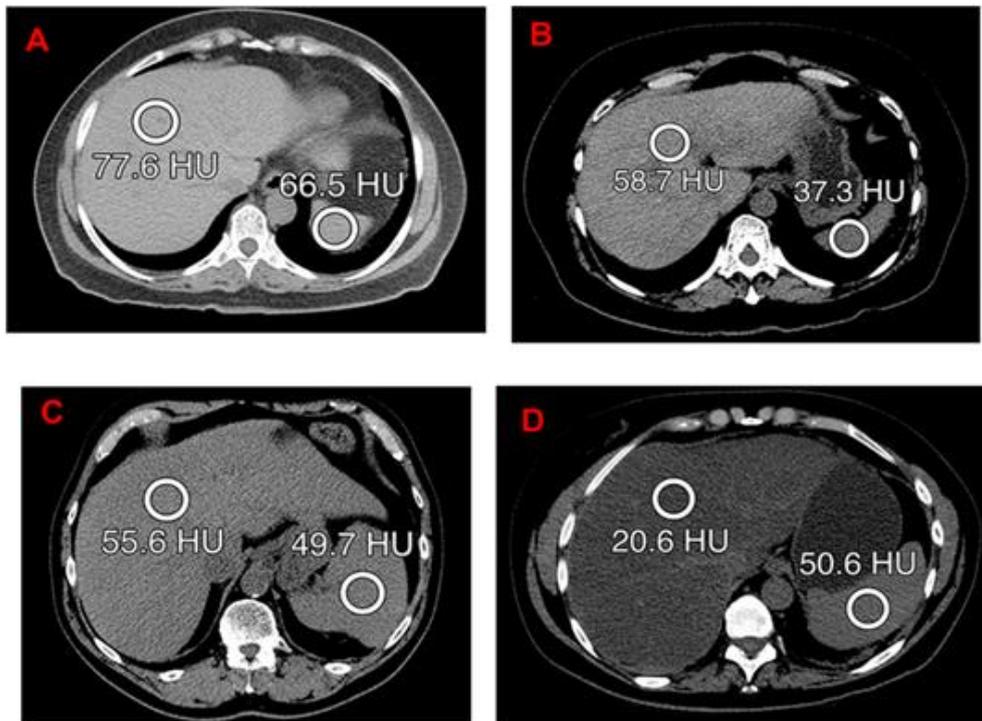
CT images of the liver at the level of the spleen, liver density on CT in Hounsfield Units decreases though spleen density in Hounsfield Units is variable
